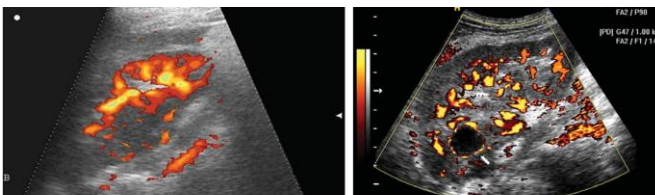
Ultrasonic Doppler of kidney in ED mode: *a - acute multifocal bacterial nephritis (acute depletion of vascular pattern in the area of inflammatory foci), b – renal abscess (anechoic formation, lack of vascular pattern in the area of inflammatory foci, perifocal increased*
